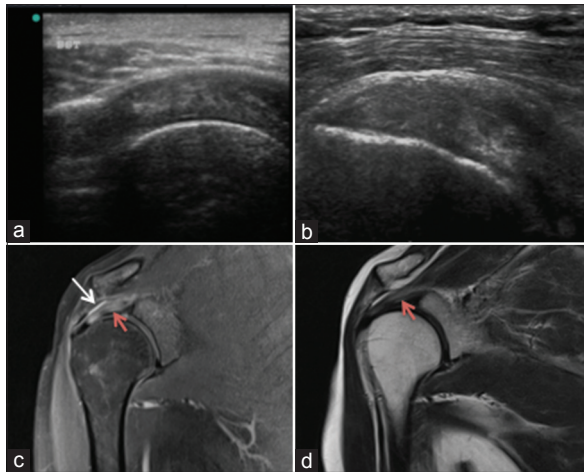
A 50-year-old female patient presented with right shoulder pain since 2 months. On clinical examination, resisted abduction produced pain suggestive of supraspinatus lesion. (a) Transverse; and (b) Longitudinal sonogram of right supraspinatus tendon demonstrated a thickened and heterogeneous tendon with loss of normal fibrillar pattern. No focal defect was noted within the tendon. (c) Coronal oblique proton density (PD) fat sat. (d) T2-weighted images (T2WI) revealed hyperintense signal within the supraspinatus tendon (red arrow) which was not as bright as fluid. There was associated subacromial-subdeltoid bursitis (white arrow)
